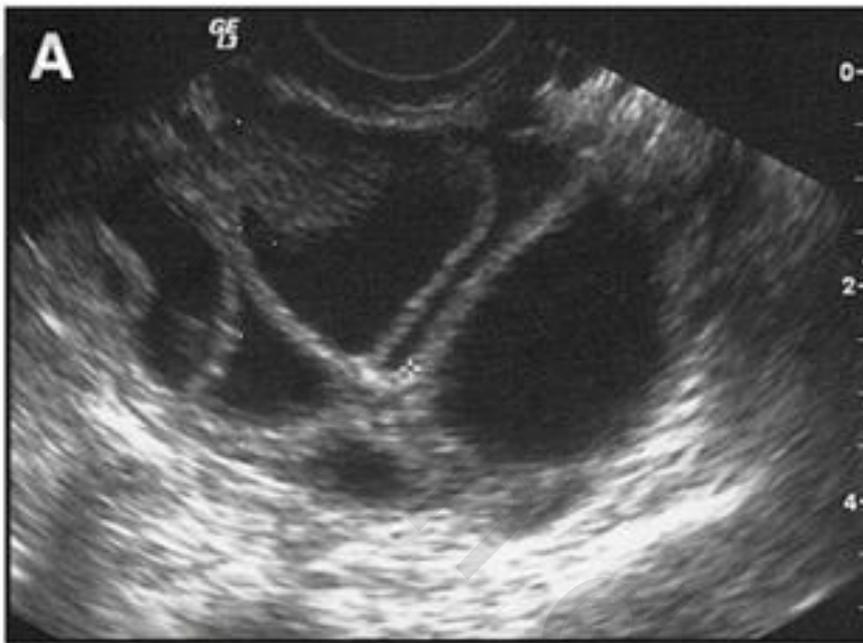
Ovarian follicles, stimulated by ovulation medications, visible on ultrasound.*
